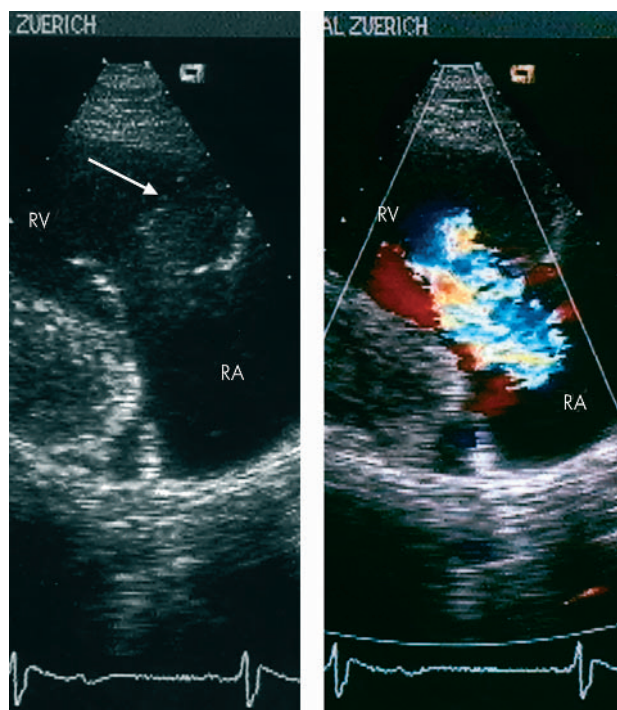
Echocardiographic atypical parasternal long axis view of the tricuspid valve apparatus. Left panel: Arrow indicates an aberrant tendinous chord tethering the anterior tricuspid leaflet. Right panel: Severe tricuspid regurgitation is detected by colour Doppler imaging, and apical displacement of the regurgitant jet origin is apparent. RA, right atrium; RV, right ventricle.
